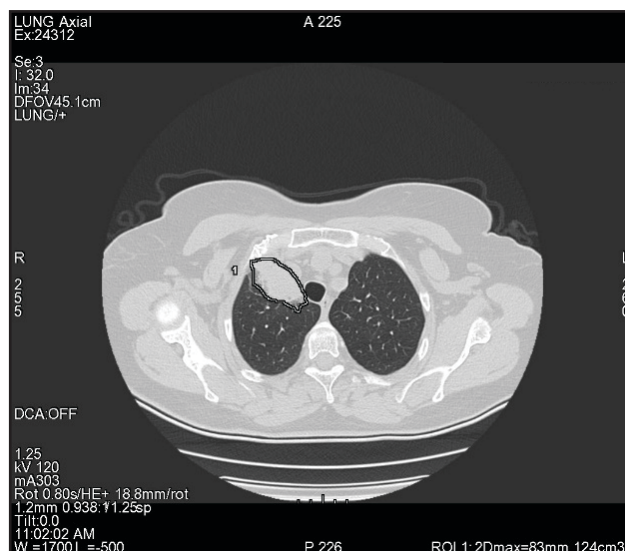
Thoracic CT scan before treatment
